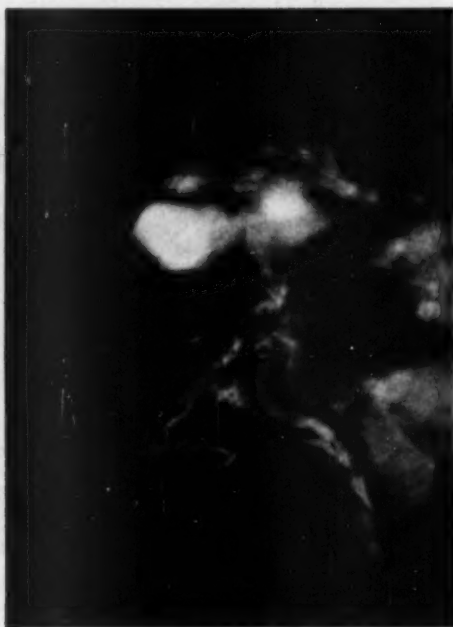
Postmortem roentgenogram of the right lung, same as Figure 5 left but with the anomalous artery injected. Note that the lower lobe is now filled. The upper lobe remains filled from the previous injection shown in Figure 5 left.
